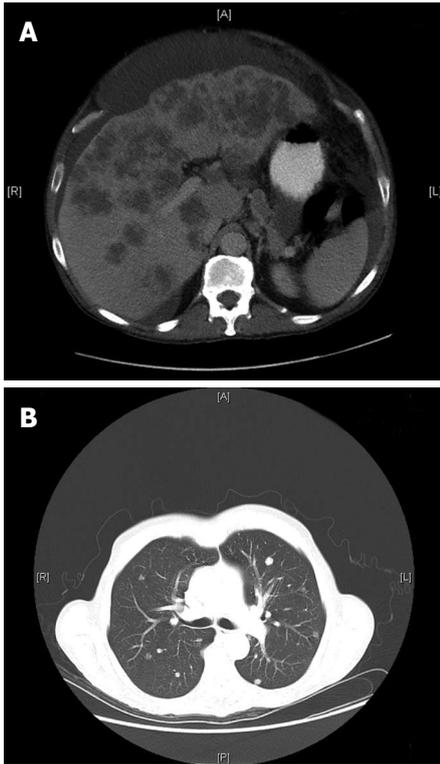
Computerized tomography. A: Computerized tomography (CT) abdomen showing a patient with rectal cancer having liver metastasis and ascites; B: CT Chest showing a patient with rectal cancer having lung metastasis.
